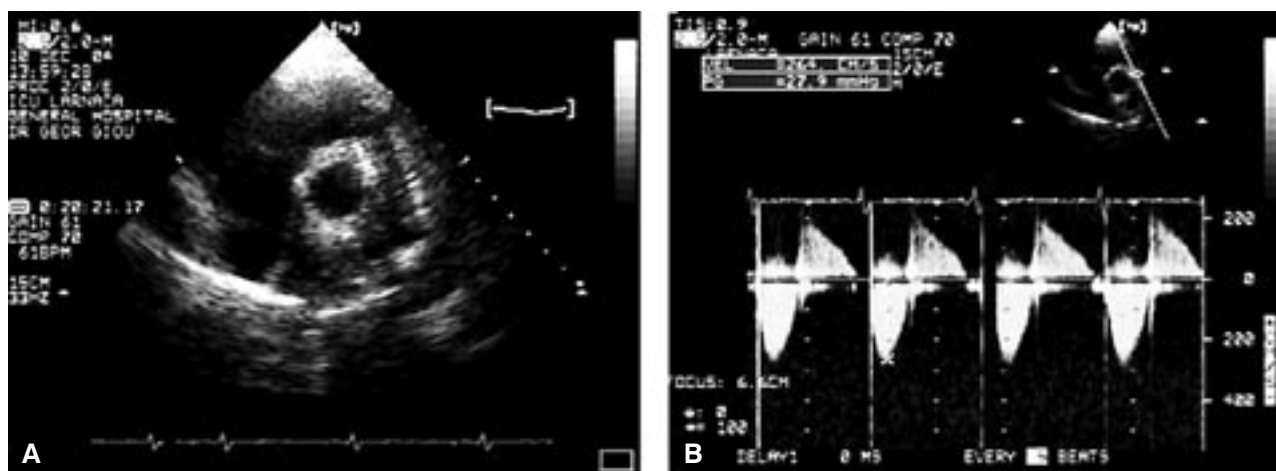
Transthoracic echocardiogram 2D- (A) and continuous-wave Doppler (B) in short axis parasternal view after stenting of the homograft, confirming significant improvement in the homograft's lumen and an impressive decrease in peak systolic gradient across it.
